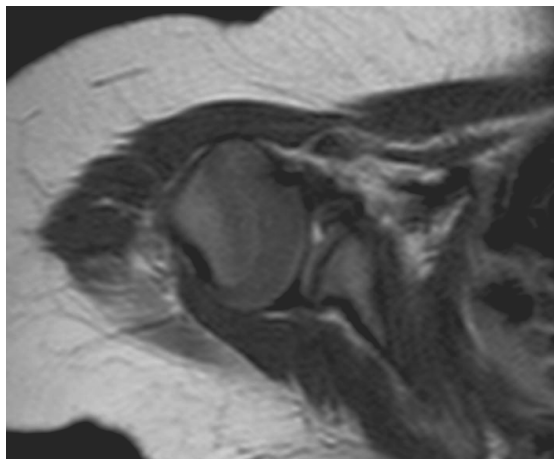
MRI image of the glenohumeral joint with a type 1 subluxation.
